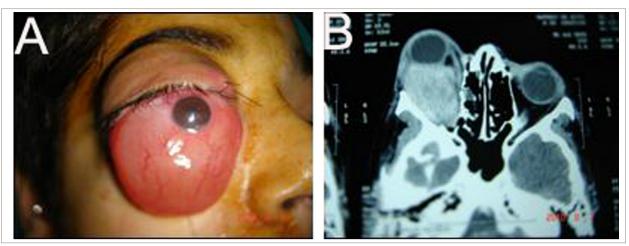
(A) Massive proptosis with eyeball pushed down grossly with restriction of motility, diffuse corneal haze and non reacting pupil. (B) CT scan of the orbit showing a well defined enhancing mass in the right retrobulbar region.
